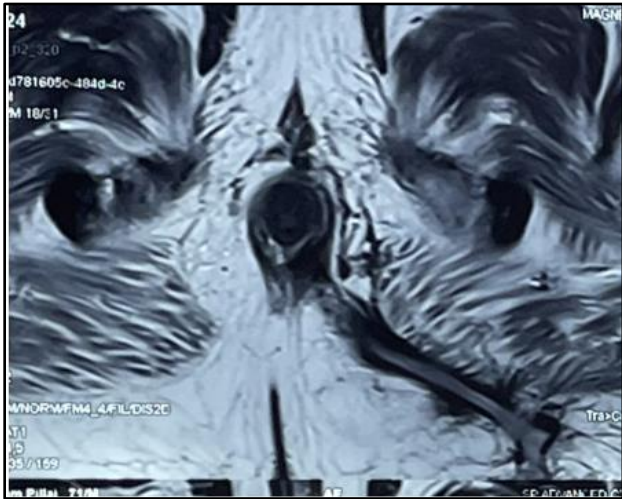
shows MRI Axial view of anal canal T2W image with complex High -Transphincteric fistula type. long tract with internal opening at 6 o'clock
